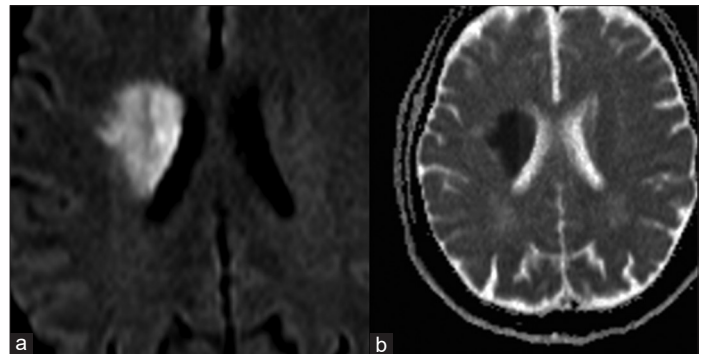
Magnetic resonance imaging diffusion-weighted imaging and ADC showing the right corona radiata and caudate body acute infarct
